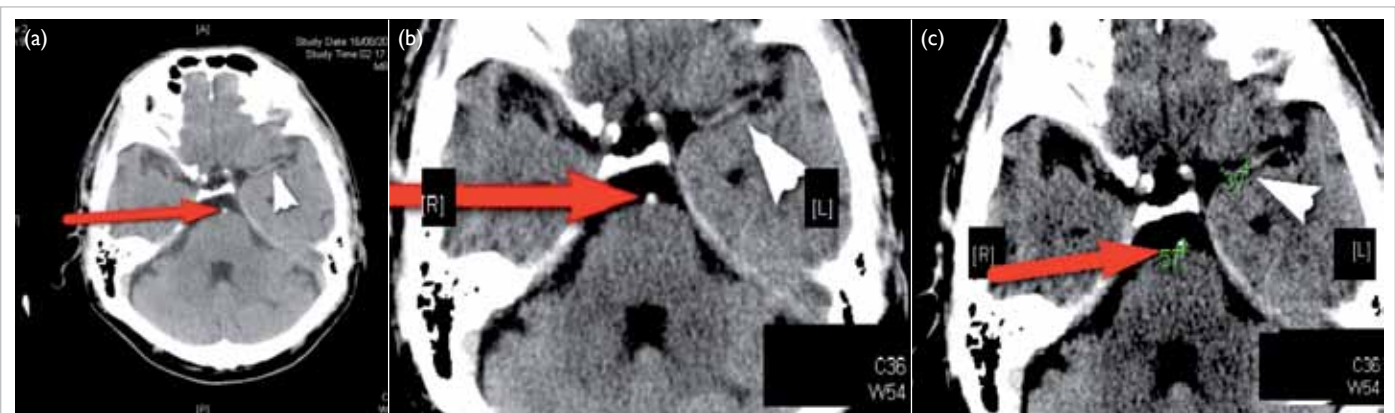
(a) An axial non-contrast computed tomography (CT) brain with usual viewing window (width 90; centre 30) shows hyperdense basilar artery (red arrow) and normal attenuation of the M1 segment of the left middle cerebral artery (MCA; white arrowhead). (b) The same CT image is magnified with its window adjusted (width 54; centre 36). Hyperdense basilar artery (red arrow) is better delineated with greater contrast with the left MCA (white arrowhead). (c) A magnified non-contrast CT brain with narrowed window shows the Hounsfield unit of the basilar artery measured 57 (red arrow) while that of the left middle cerebral artery measured 37 (white arrowhead)
